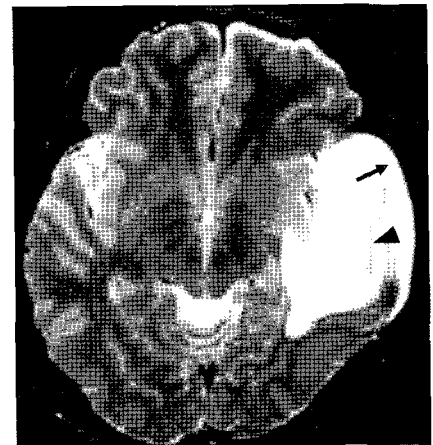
Axial magnetic resonance(MR) image showing an arachnoid cyst in the left middle cranial fossa, which is hyperintense on the T2-weighted image. Note the crescent mass (arrow) bordered by linear membrane (arrowhead).
